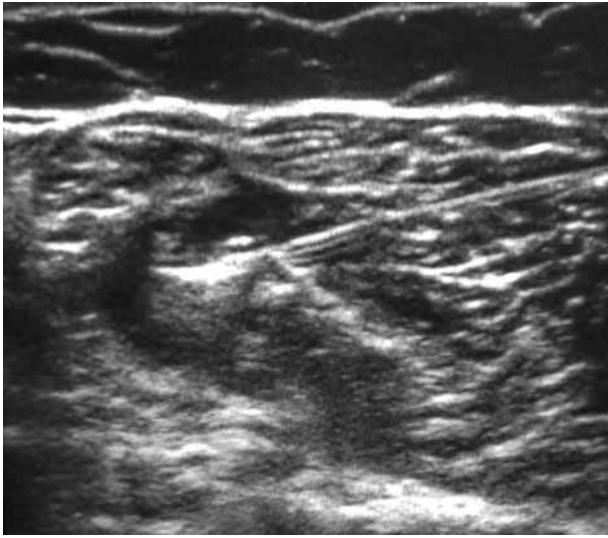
Ultrasonography showing the tip of the hypodermic needle in the peritendinous tissue
